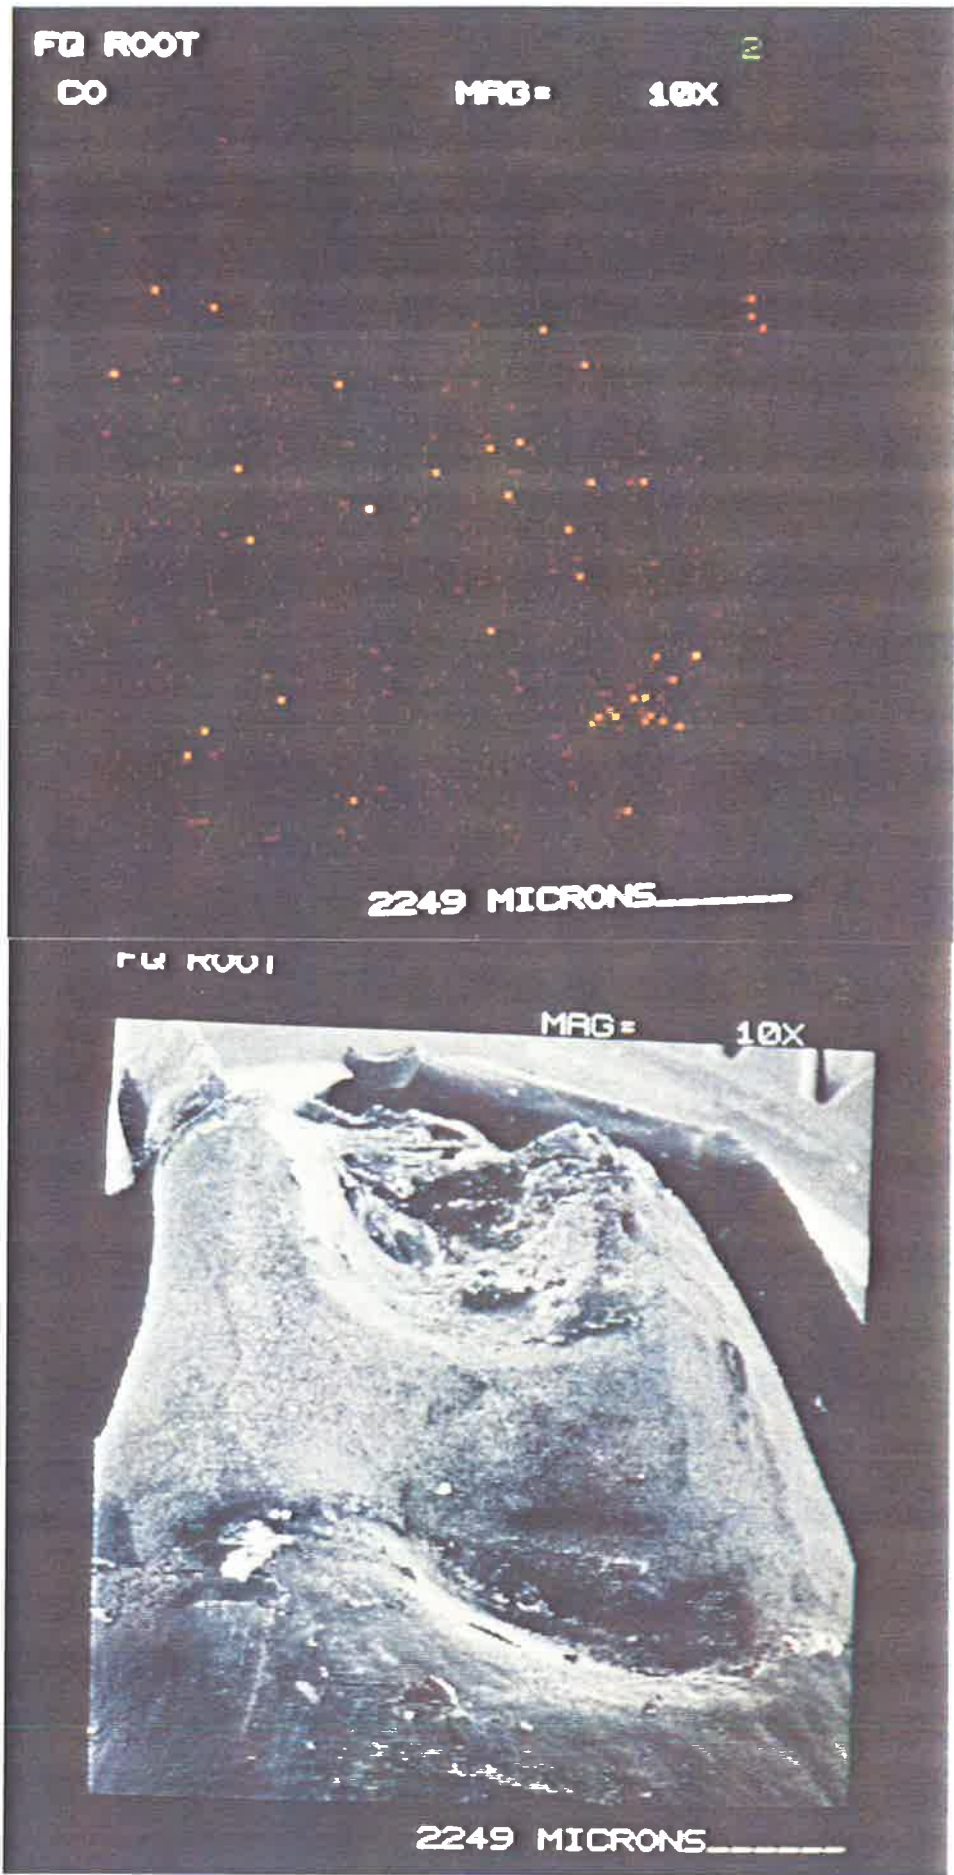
X-Ray Image Representing a Score of Zero (SEM Image top).
